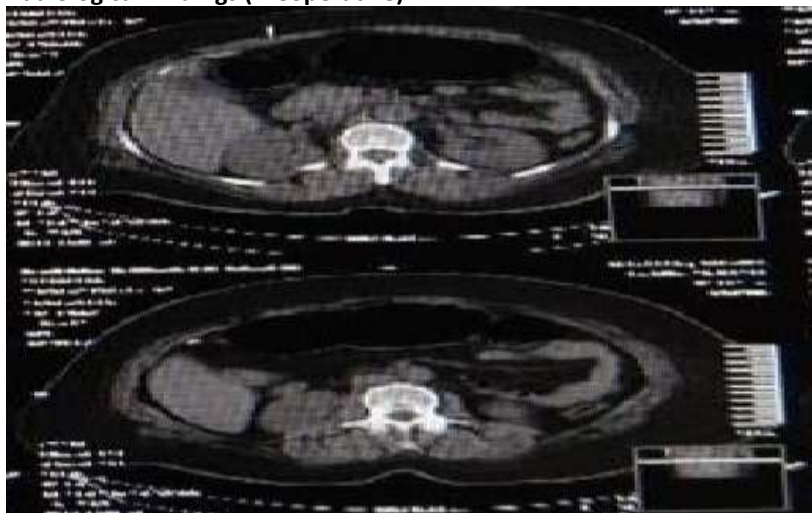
CT abdomen and pelvis
